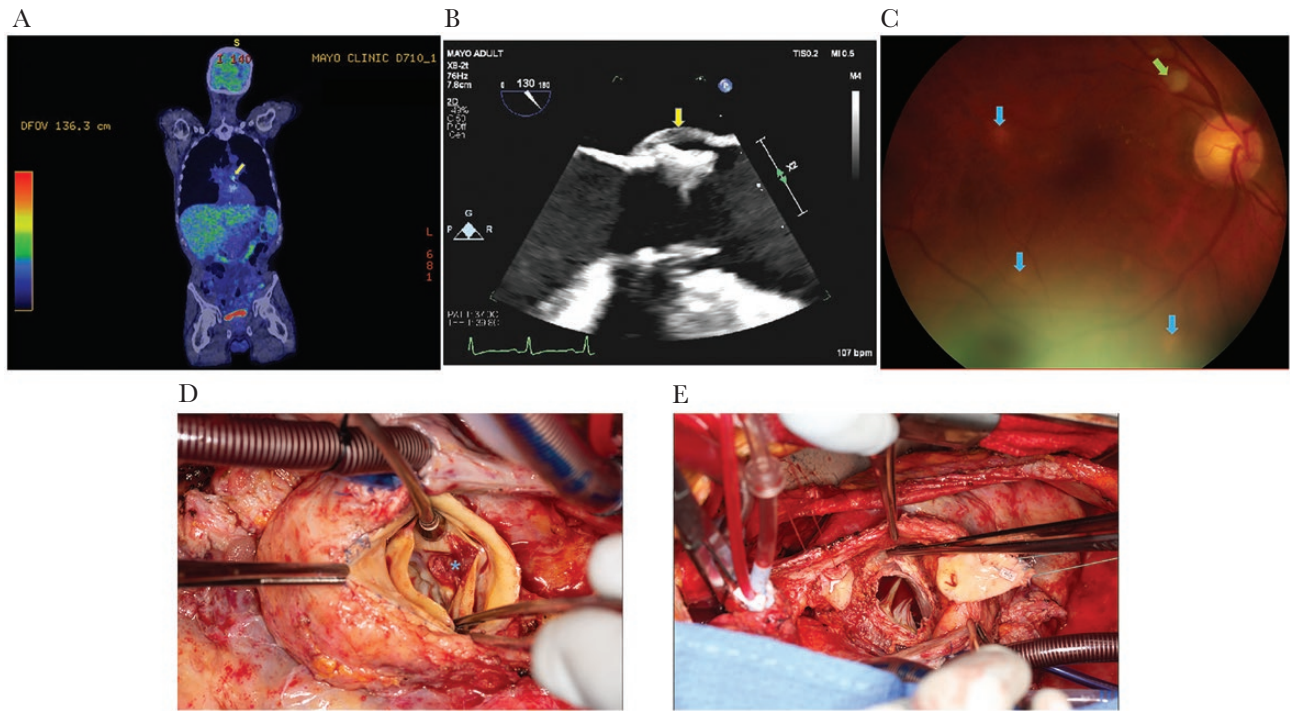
Representative images of diagnostic workup and treatment of a patient with MCI. A 66-year-old man presented with 8 months of fever, nightsweats, and progressive weight loss; he had aortic valve replacement and LAA occlusion 13 months before symptom onset. PET/CT (A) showed focal FDG uptake in the LAA occlusion device (yellow arrow) but no uptake in the aortic valve prosthesis; normal uptake was noted in the liver and spleen. TEE (B) showed minimal thickening in the mitral-aortic intervalvular fibrosa (yellow arrow), inconclusive for endocarditis. Color fundus photography (C) on ophthalmologic examination revealed bilateral chorioretinal lesions (blue arrows); a cotton wool spot associated with the patient's bicytopenia was also noted. Blood cultures eventually returned positive for *M. chimaera*. Redo median sternotomy was performed. A phlegmon (*) was seen in the noncoronary cusp of the aortic valve prosthesis (D). Following resection of the prosthesis, an aortic root abscess with almost complete destruction of the aortic annulus was found (E). Abbreviations: FDG, fluorodeoxyglucose; LAA, left atrial appendage; MCI, *Mycobacterium chimaera* infection; PET/CT, positron emission tomography/computed tomography; TEE, transesophageal echo.
